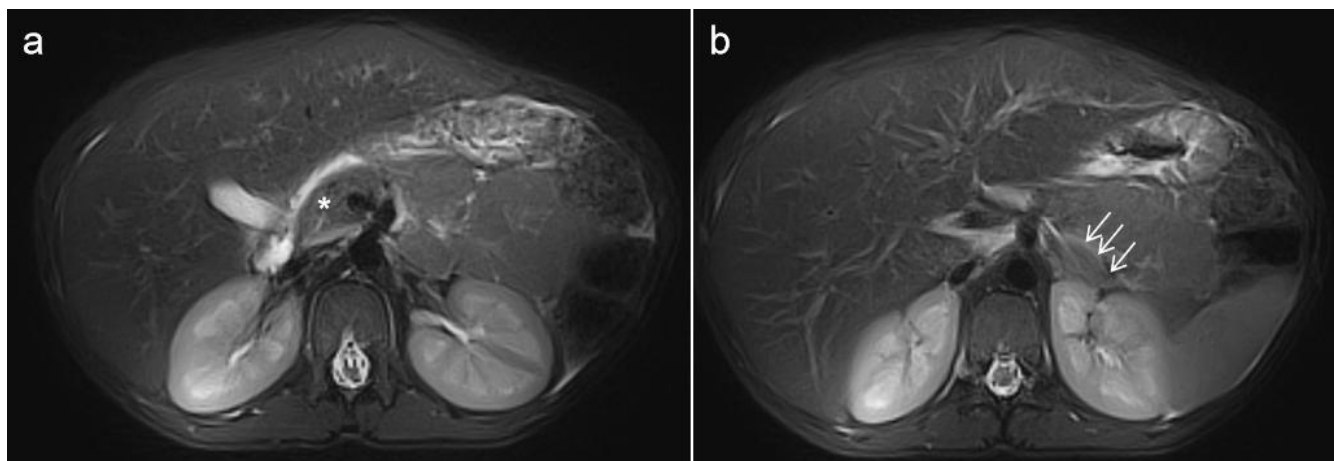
Representative T2-weighted PROPELLER MRI findings in a 10-year-old boy with clinically suspected type 5 diabetes mellitus. (a) Relative preservation of the pancreatic head (asterisk). (b) Shortened distal pancreas with reduced extension of the pancreatic tail toward the splenic hilum (white arrows)
